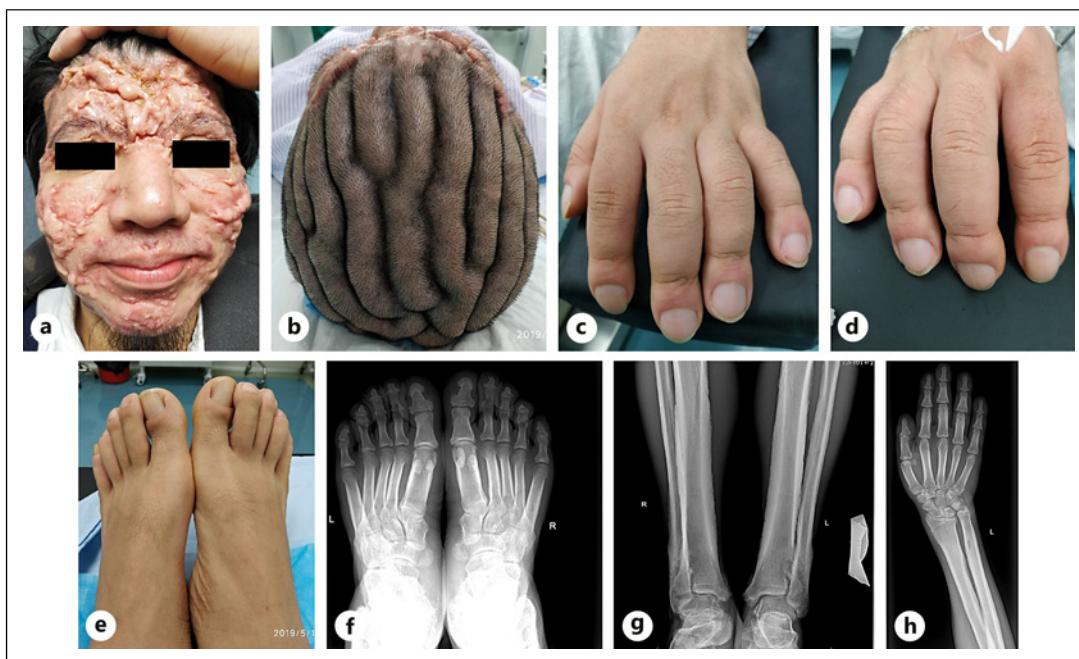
a Facial appearance of the patient. b Marked thickening of the scalp (cutis verticis gyrata). c–e Clubbing of the fingers and toes. f–h Radiograph of the ankles, hands, and feet showing extensive periostosis.
